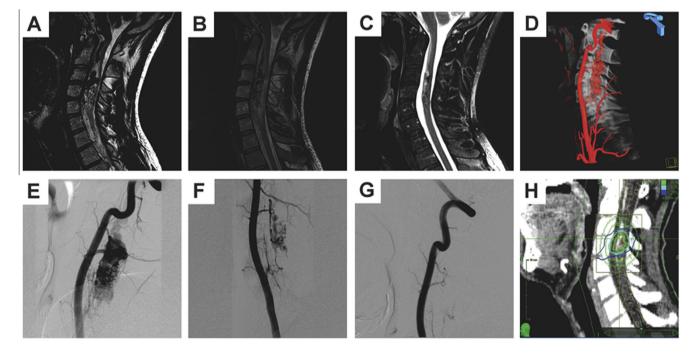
Radiosurgery of a C3–C5 intramedullary Type II arteriovenous malformation (AVM) in an 18-year-old man. (A) Sagittal T2-weighted pretreatment MRI of the cervical spine demonstrating intramedullary flow voids from C3–C5 expanding the spinal cord. (B) Sagittal cervical spine MRI 3 years post-radiosurgery to the AVM. (C) Sagittal T2-weighted MRI showing obliteration of >95% of AVM flow voids 3 years following the second treatment. (D) Three-dimensional (3D) angiogram of the left vertebral artery demonstrating the AVM nidus and its relationship with spinal bony anatomy. Treatment planning completed based on these 3D images. (E) Lateral projection left vertebral artery angiogram with a segmental radiculomedullary feeder supplying the AVM nidus. (F) Left vertebral artery angiogram showing significant decrease (>75%) in size of AVM nidus. The patient was subsequently treated with another radiosurgery session. (G) Left vertebral artery angiogram showing complete obliteration of AVM nidus after the second treatment. (H) Sagittal post-contrast CT scan with CyberKnife (Accuray, Sunnyvale, CA, USA) treatment planning contours with 80% (green) and 50% (light blue) isodose lines.
